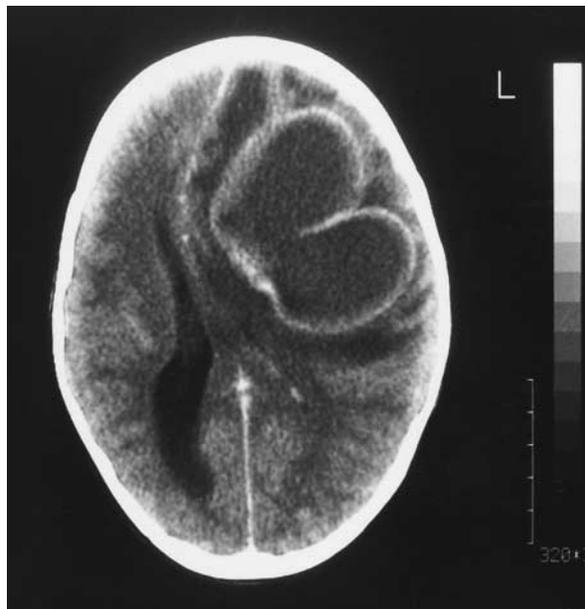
Contrast-Enhanced Computed Tomographic Scan of the Head of a Child, Showing a Large, Ring-Enhancing Lesion in the Left Frontoparietal Area with Edema and Mass Effect.
